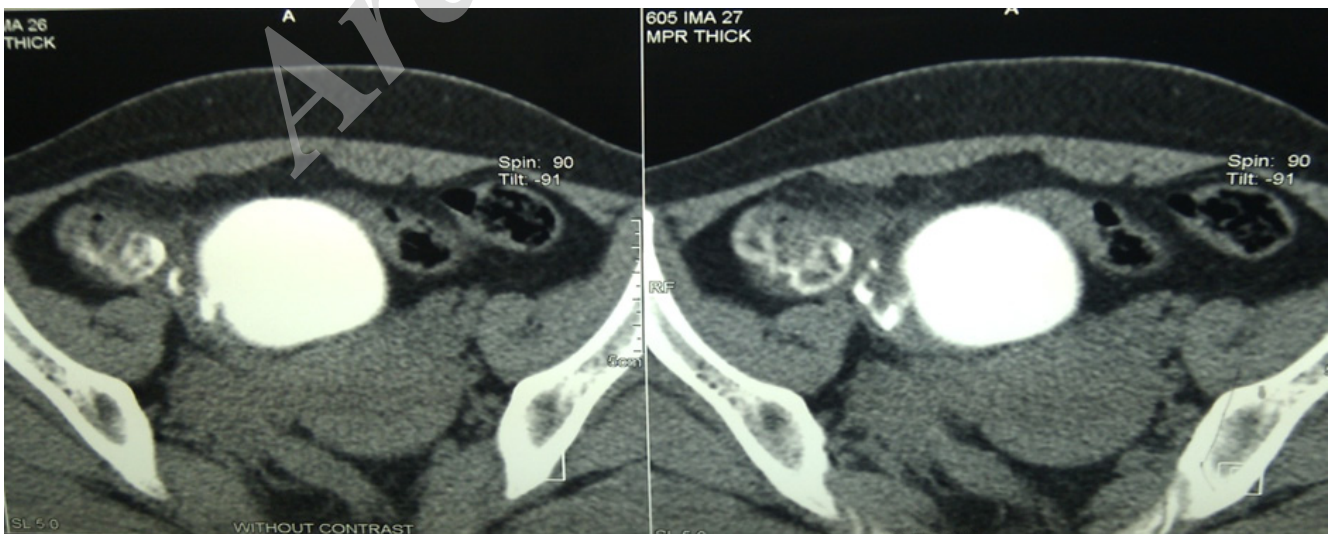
Transverse view of cecum, bladder and fistula in computed tomography cystography.
